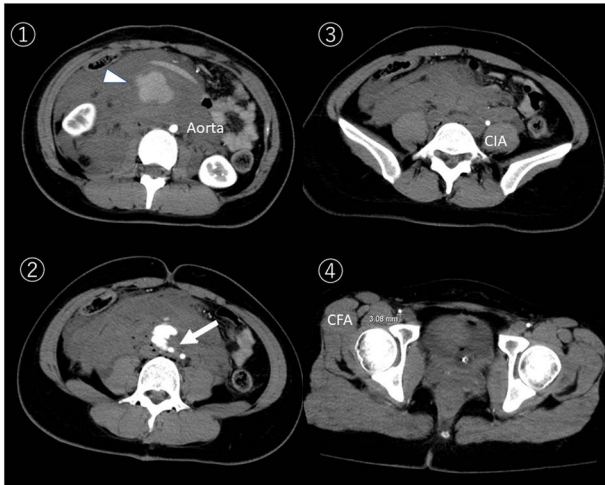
Preoperative enhanced computed tomography showed a large retroperitoneal hematoma (arrowhead) and extravasated contrast from the right common artery injury (white arrow). The aorta, iliac artery and femoral artery were very small at 8mm, 5mm and 3mm respectively. Photos are numbered from the head side.
